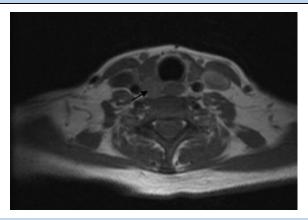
B. MRI of the neck, sagittal section. A 10×15 mm mass is observed behind the thyroid gland (small black arrow).
